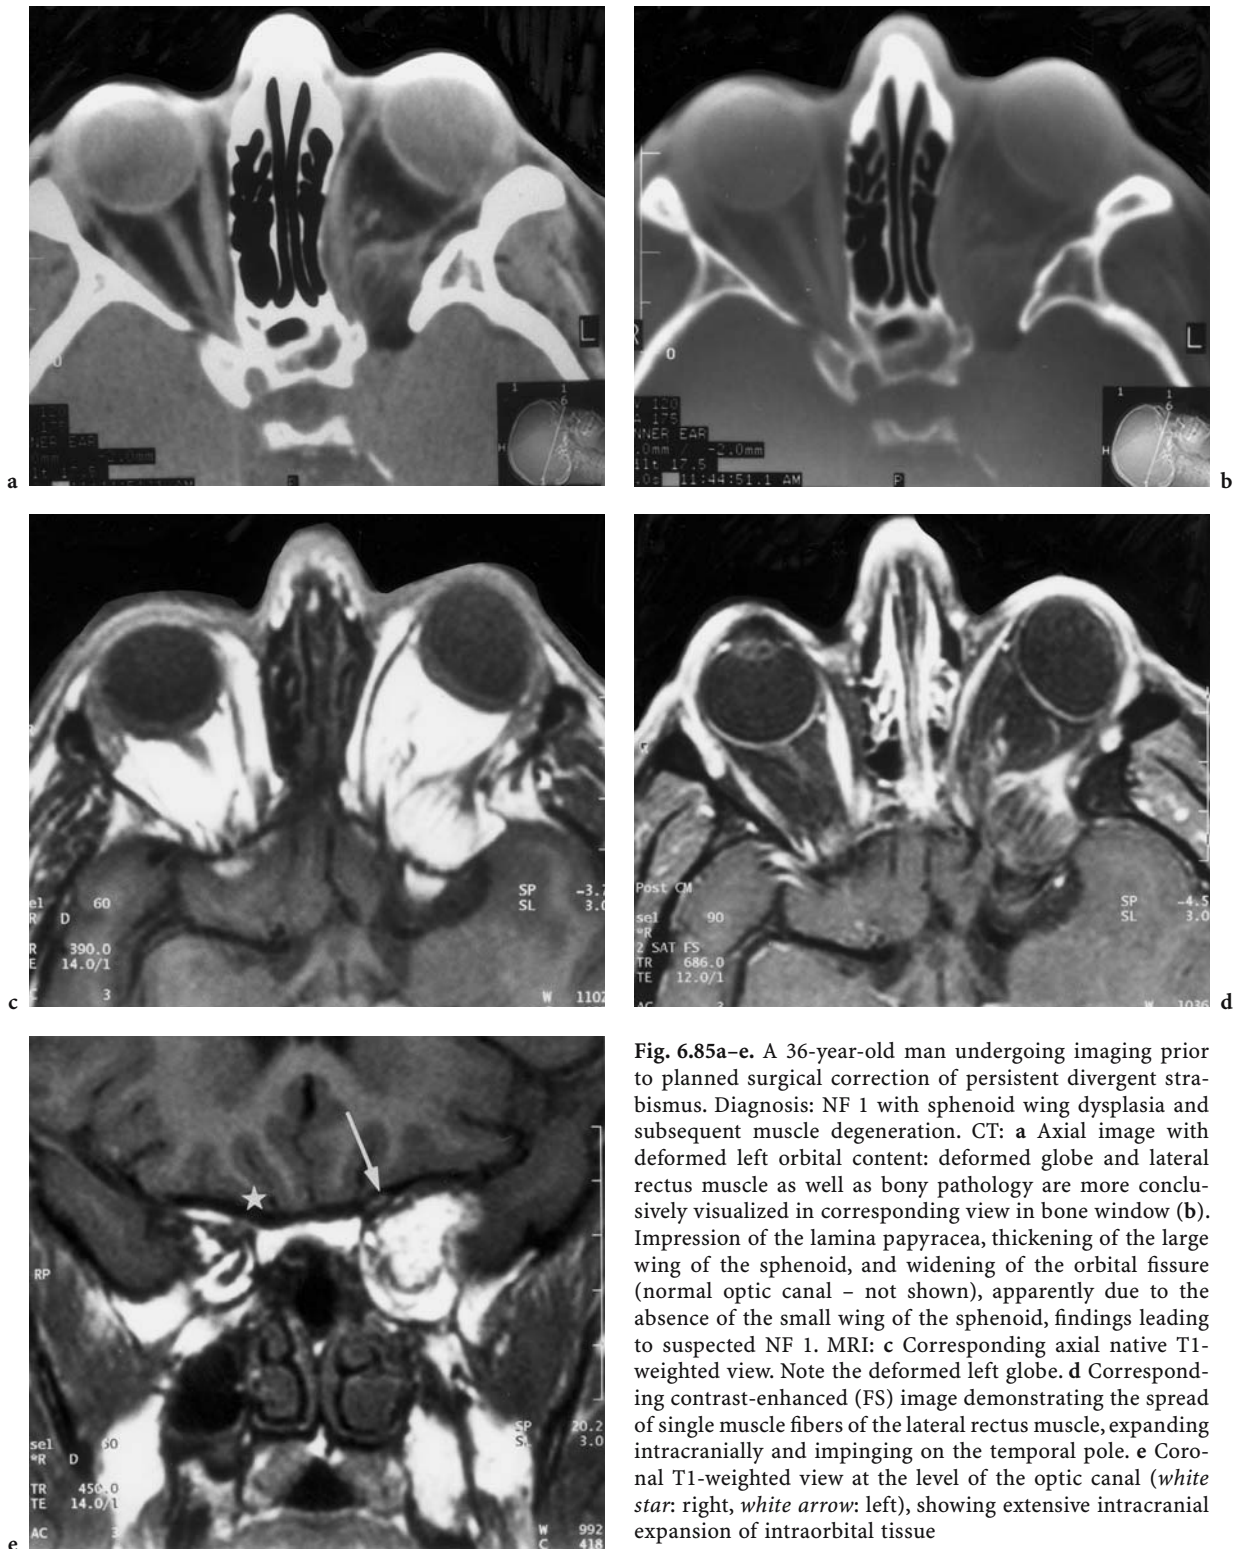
A 36-year-old man undergoing imaging prior to planned surgical correction of persistent divergent strabismus. Diagnosis: NF 1 with sphenoid wing dysplasia and subsequent muscle degeneration. CT: a Axial image with deformed left orbital content: deformed globe and lateral rectus muscle as well as bony pathology are more conclusively visualized in corresponding view in bone window (b). Impression of the lamina papyracea, thickening of the large wing of the sphenoid, and widening of the orbital fissure (normal optic canal – not shown), findings leading to suspected NF 1. MRI: c Corresponding axial native T1-weighted view. Note the deformed left globe. d Corresponding contrast-enhanced (FS) image demonstrating the spread of single muscle fibers of the lateral rectus muscle, expanding intracranially and impinging on the temporal pole. e Coronal T1-weighted view at the level of the optic canal (*white star*: right, *white arrow*: left), showing extensive intracranial expansion of intraorbital tissue
